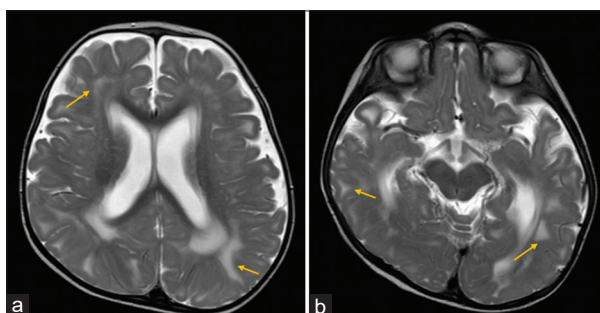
(a) Axial T2 fluid-attenuated inversion recovery (FLAIR) images show periventricular, deep and subcortical white matter hyperintensities involving bilateral frontal and parietal lobes; and (b) axial T2 FLAIR images show periventricular, deep and subcortical white matter hyperintensities involving bilateral temporal lobes
